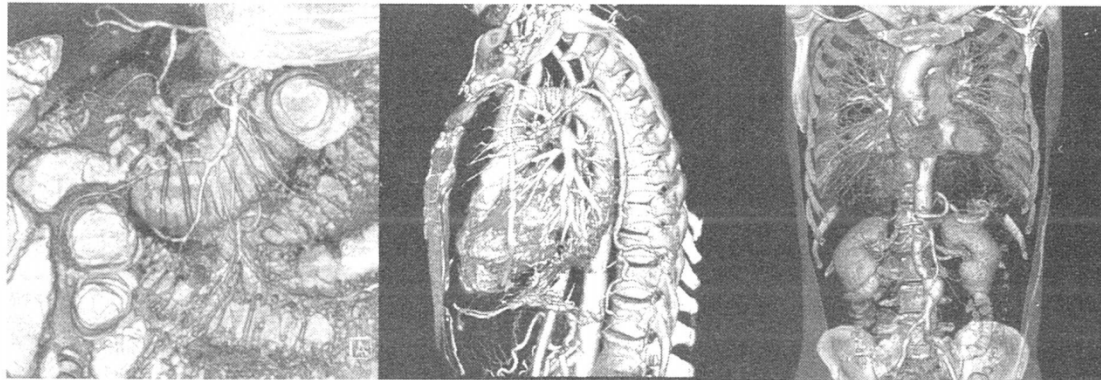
Abdominal, thoracic, and vascular CT images obtained using the Somatom Sensation multi-slice scanner. Images courtesy of Siemens Medical Systems.
